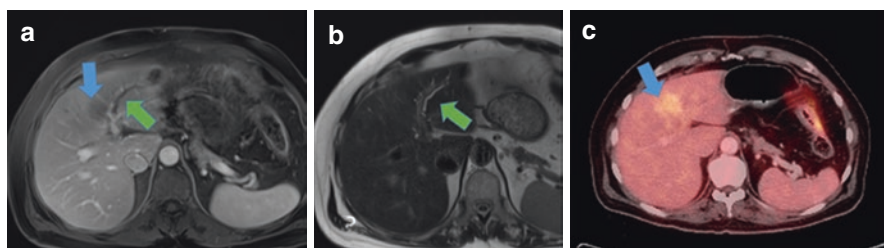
Intrahepatic cholangiocarcinoma with mass-forming growth pattern demonstrates the common finding of suspicious segmental biliary ductal dilation (green arrow) with associated indistinct mass (blue arrow) that demonstrates hypoenhancement on the T1 FS image (a), indistinct mild T2 hyperintensity (b), and moderate-to-intense FDG uptake on the fused PET/CT image (c)
